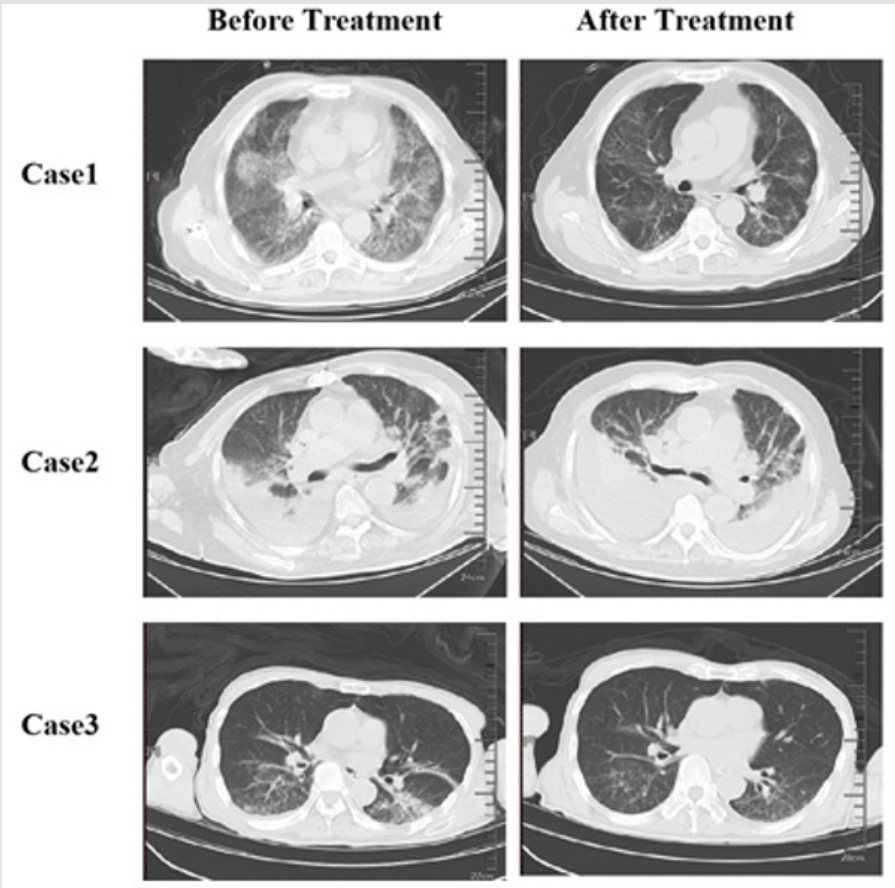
Changes of Chest CT Imaging in 3 Cases.
